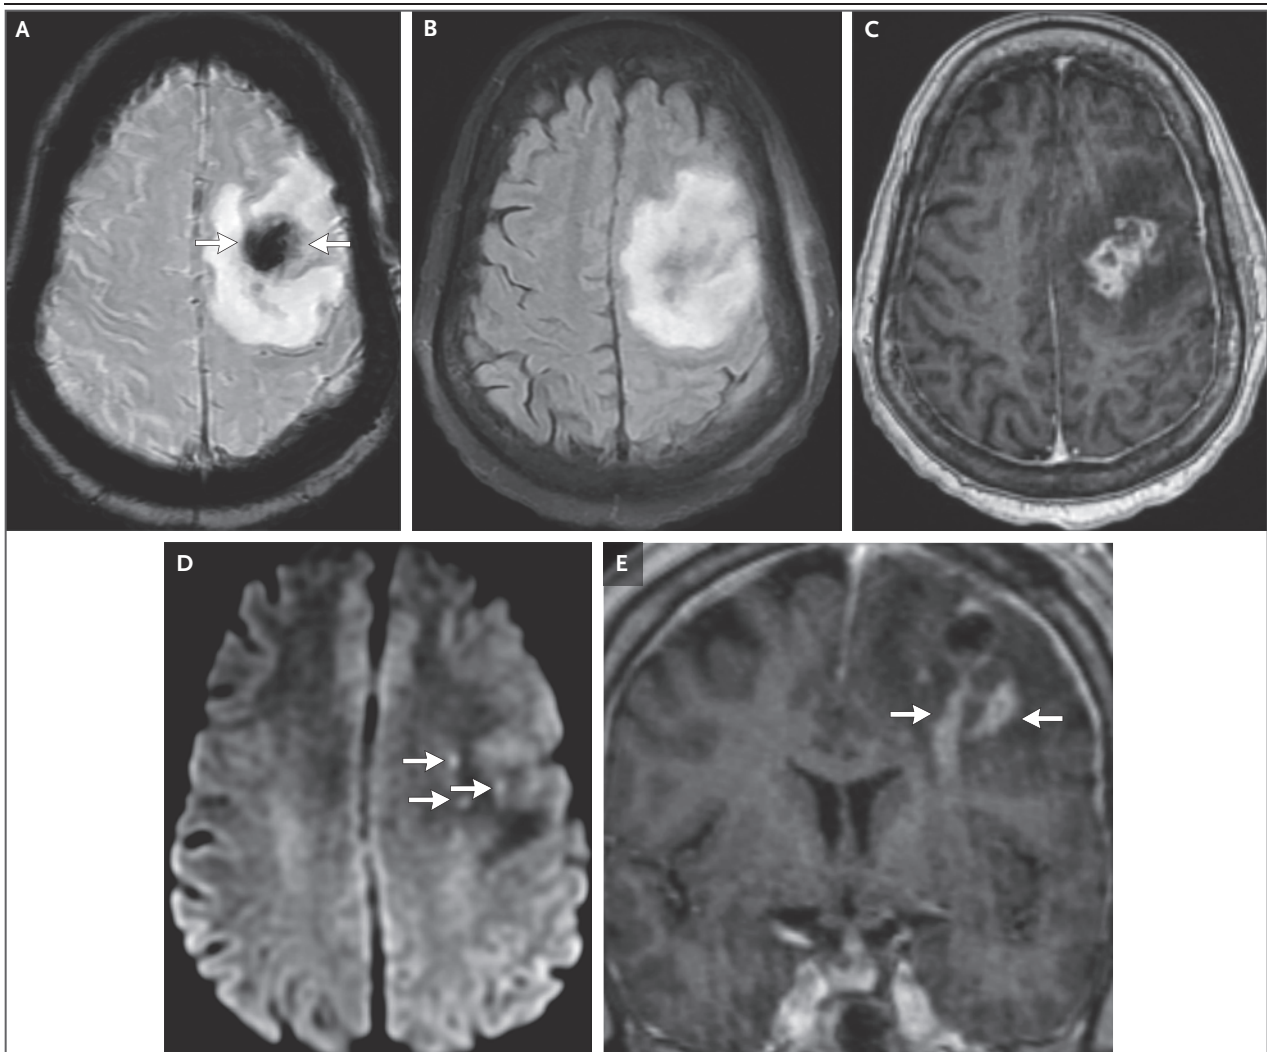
MRI of the Head Obtained on Postoperative Day 1.
